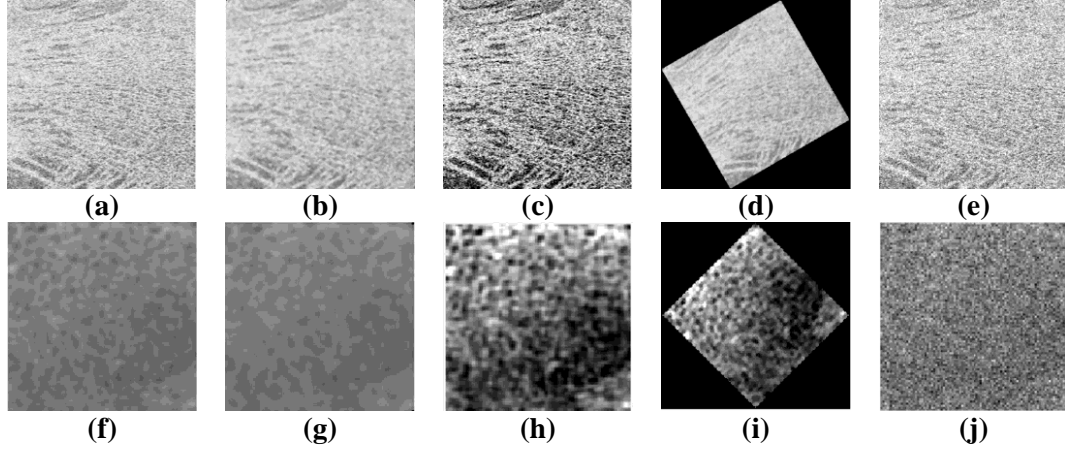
Two samples of bone MRI (first row) and X-Ray images (second row) textures of healthy subjects: (a) and (f): Original input textures; (b) and (g): Preprocessed with the median filter (MF); (c) and (h): Preprocessed with the contrast enhancement (CE); (d): Preprocessed MRI with (MF) and rotated 30° , (i): Preprocessed X-Ray images with (CE) and rotated 45° , (e): Noisy MRI, (j): Noisy X-Ray images.
